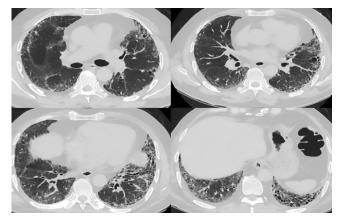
Thorax CT scan after medication revision
